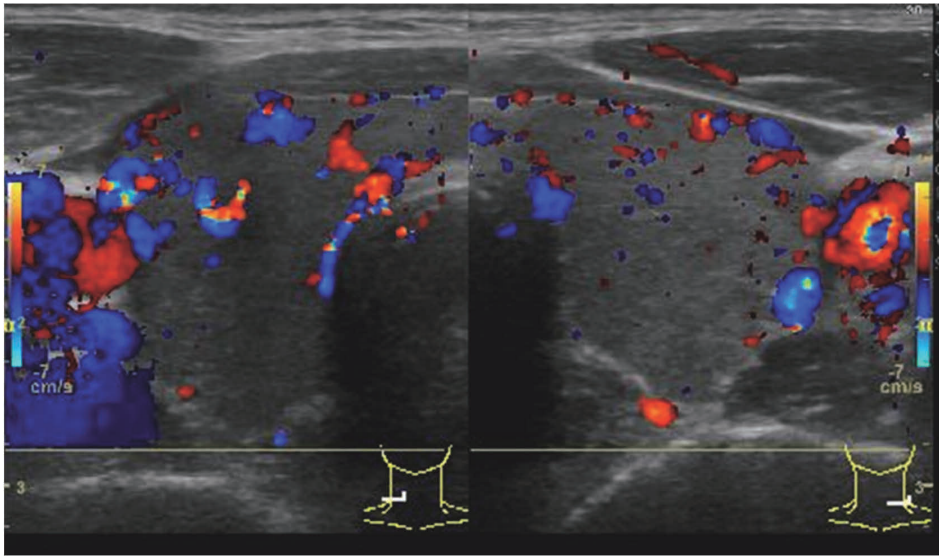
Ultrasonography of the thyroid gland showing heterogeneous internal echo and slightly increased of blood flow.
